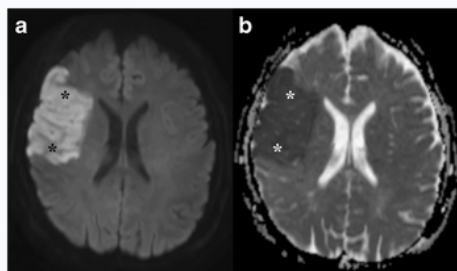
Acute Stroke –a. Increased signal intensity on DWI which corresponds the area of low ADC value in tracer image and b.darker in ADC map.
